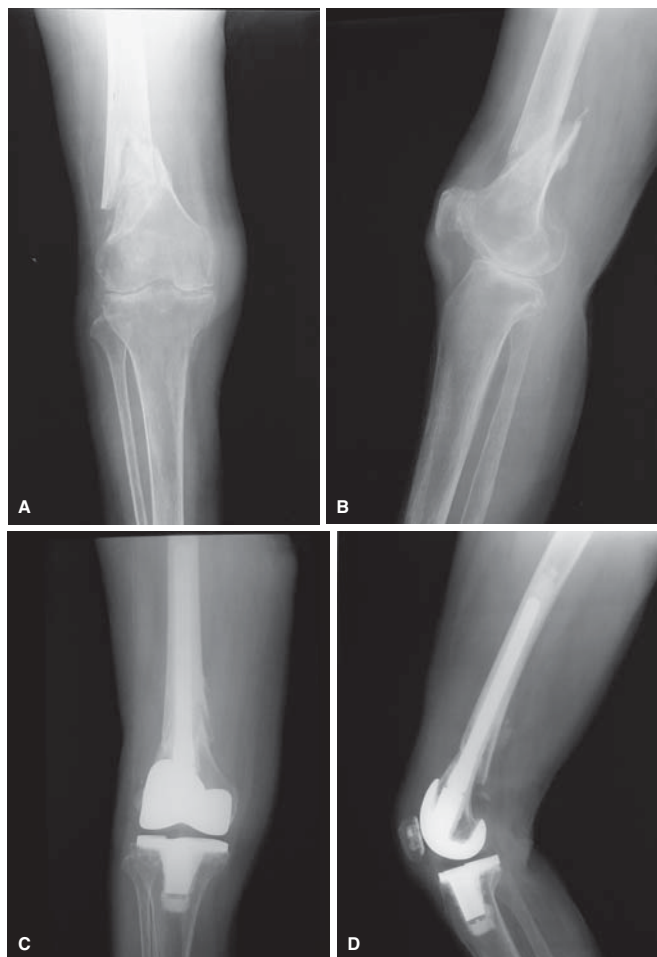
Case 3. Anteroposterior and lateral radiographs (A and B, respectively) showed a displaced supracondylar fracture of the right femur. Six months postoperatively, anteroposterior and lateral radiographs (C and D) showed stable components and good alignment of the right knee
